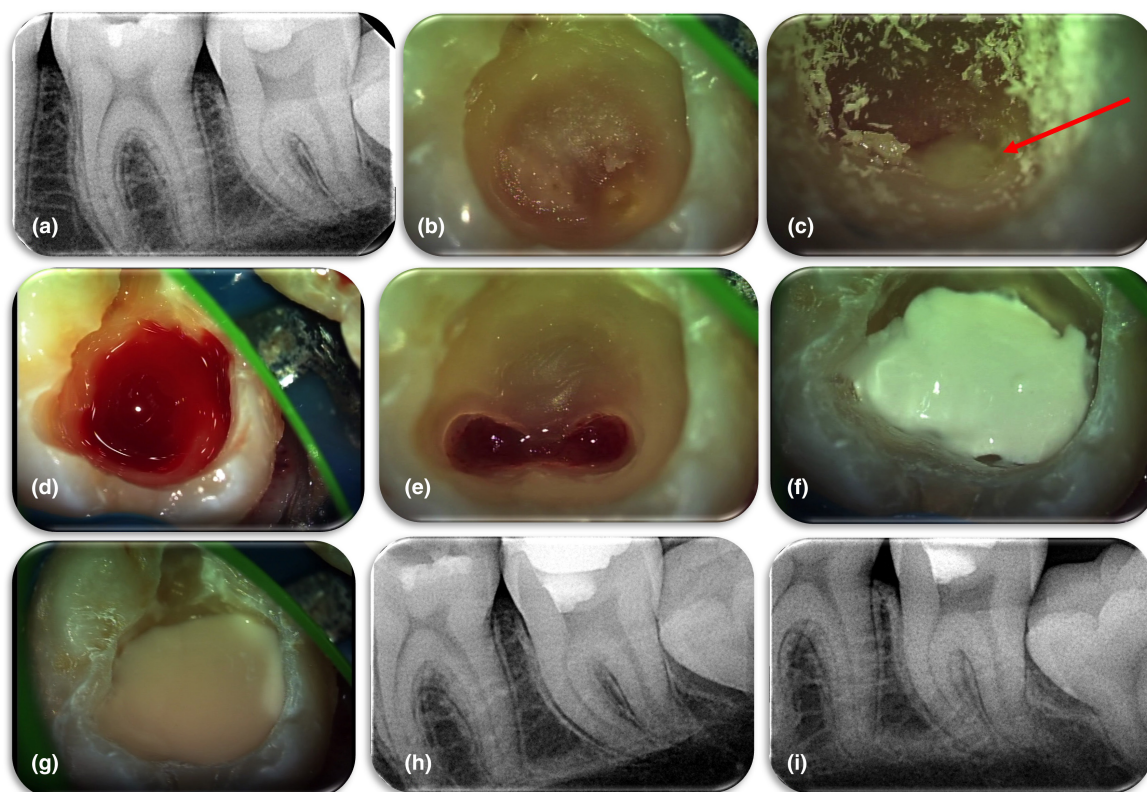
(a) Initial radiograph of a mature second mandibular molar of a 22-year-old patient with symptoms of spontaneous pain and sleep disturbance, (b) clinical figure of the tooth after partial caries removal (extremely deep caries under the permanent restoration), (c) Pus drainage after communication with pulp chamber during caries removal, (d) complete caries removal and sufficient control of bleeding, (e) placement of Total Fill BC over the coronal pulp tissue, (f) Postoperative radiograph of the case, (g) 36-month recall radiograph of the case, the patient is symptom-free, and the tooth is functional and responds normally to EPT.
